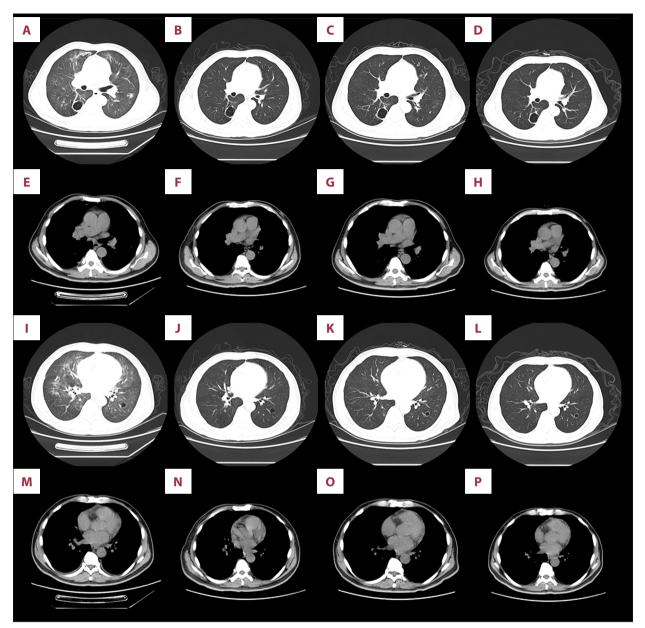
Thoracic CT scans of this case. Column denotes different parts of the lungs (lung window and mediastinal window) and row denotes different scan time. From I to L, the scan interval was about 15 days.
